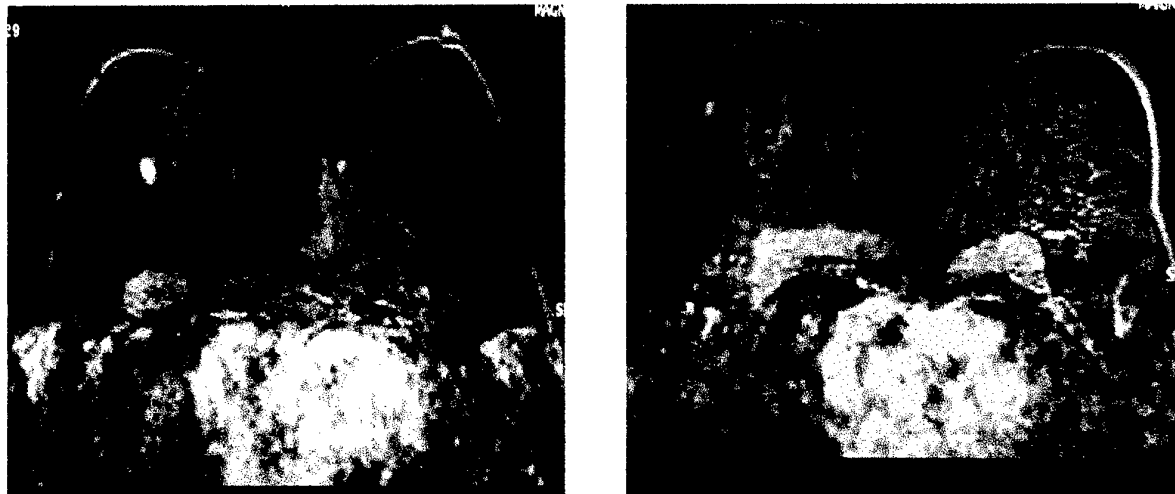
Pre and Post laser MRI scans showing signal loss within the region of the original tumour with a surrounding rim of enhancement.
